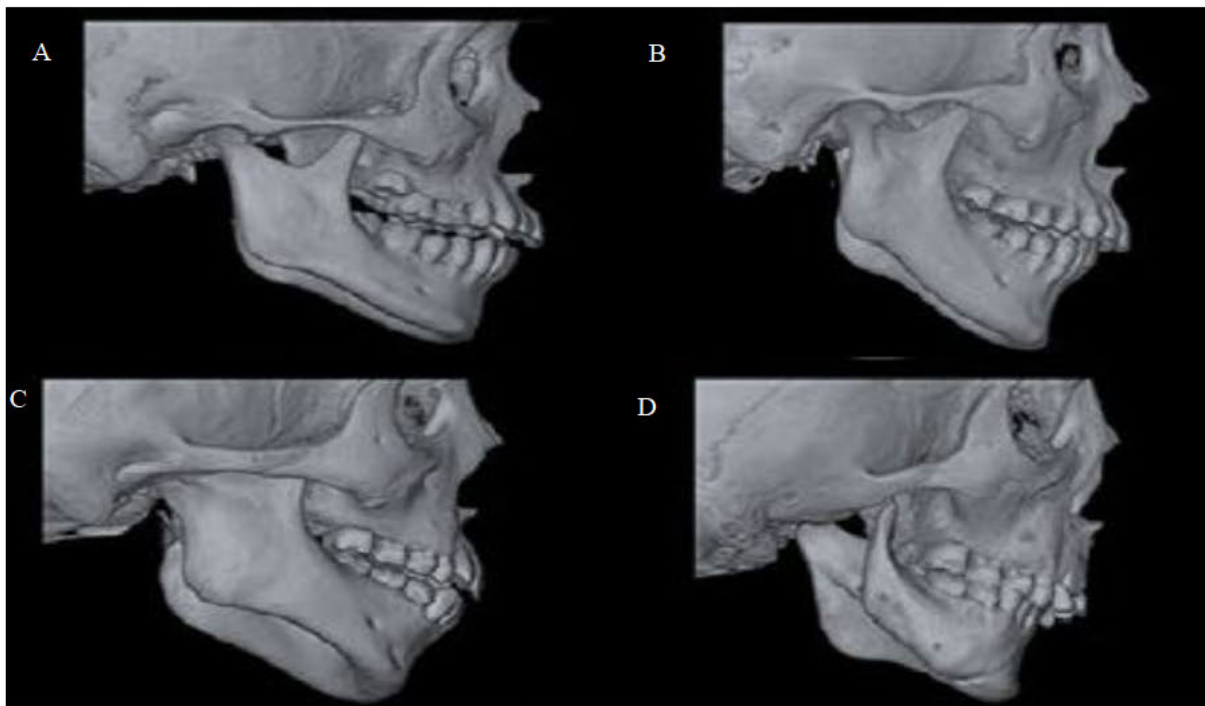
Reconstructed three-dimensional computed tomography scan of the Pruzansky-Kaban classification of hemifacial microsomia. (A) Pruzansky-Kaban grade I, (B) Pruzansky-Kaban grade IIA, (C) Pruzansky-Kaban grade IIB, (D) Pruzansky-Kaban grade III.
